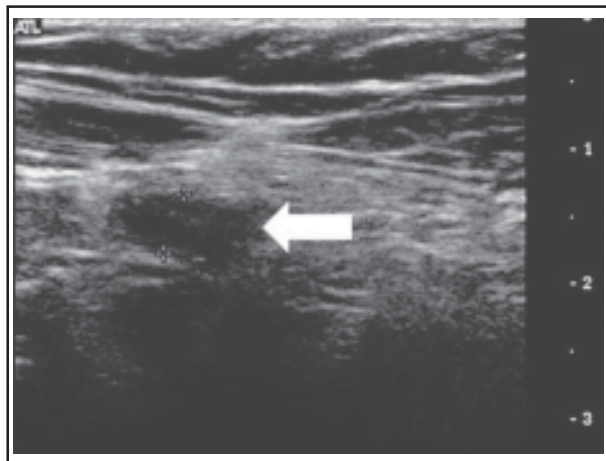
Ultrasound of abdomen demonstrated a non-compressible, dilated blind-end tubular structure, about 0.5 cm in diameter (white arrow), over right lower quadrant (RLQ) of the abdomen.
